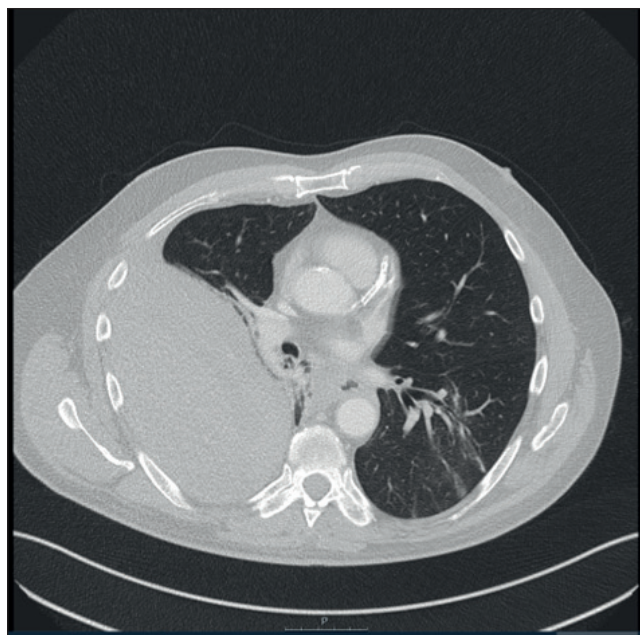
CT scan of chest, showing right posterolateral extrapleural haematoma
